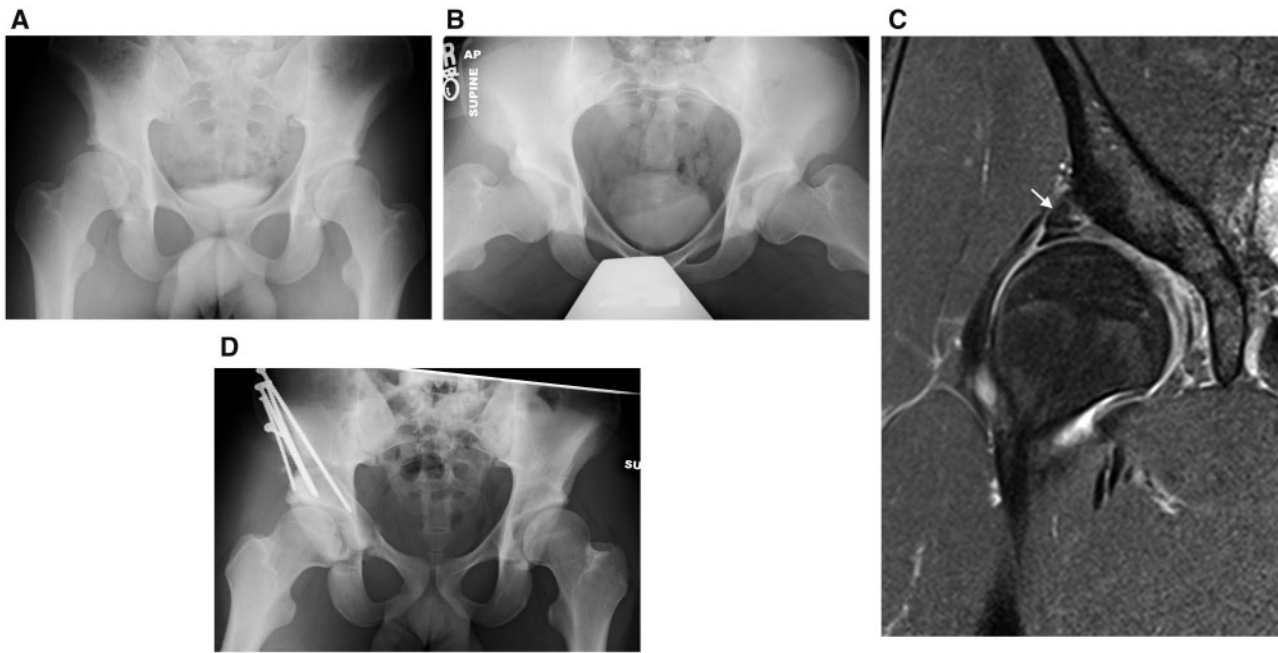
A 21-year-old male wrestler with 16-month history of right hip pain. (A, B) AP and lateral projections of the pelvis demonstrate dysplasia with a CE angle of 15 and accompanying os acetabulum on the right. (C) Coronal MRI image reveals labral pathology (arrow). (D) Post-operative AP pelvis view demonstrates correction with improved coverage of the femoral head.
